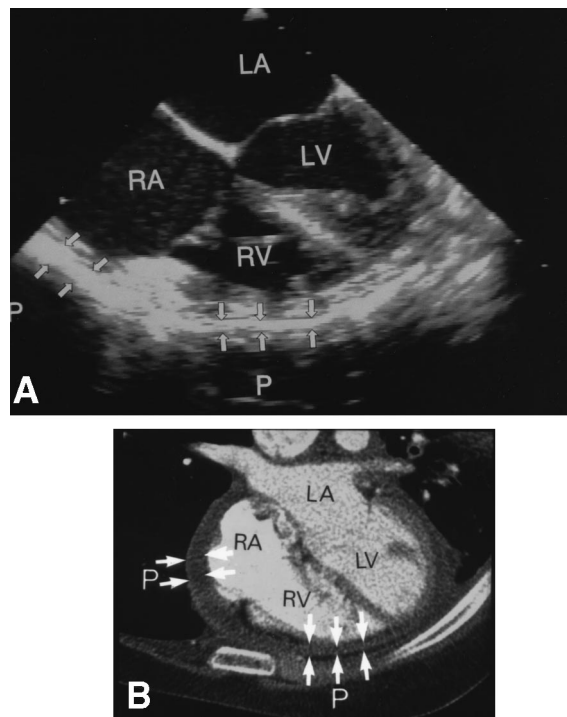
A, Transesophageal echocardiogram from Patient 1 (see Table 1) showing thickened parietal pericardium (P, arrows) overlying right ventricle (RV) and right atrium (RA) in four-chamber transverse plane view. Pericardium appears as a highly echo-dense, "fibrotic" structure. Right atrial wall is tethered to adjacent thickened pericardium. B, The corresponding transaxial electron beam computed tomographic scan showing findings similar to those in A. LA = left atrium; LV = left ventricle.
